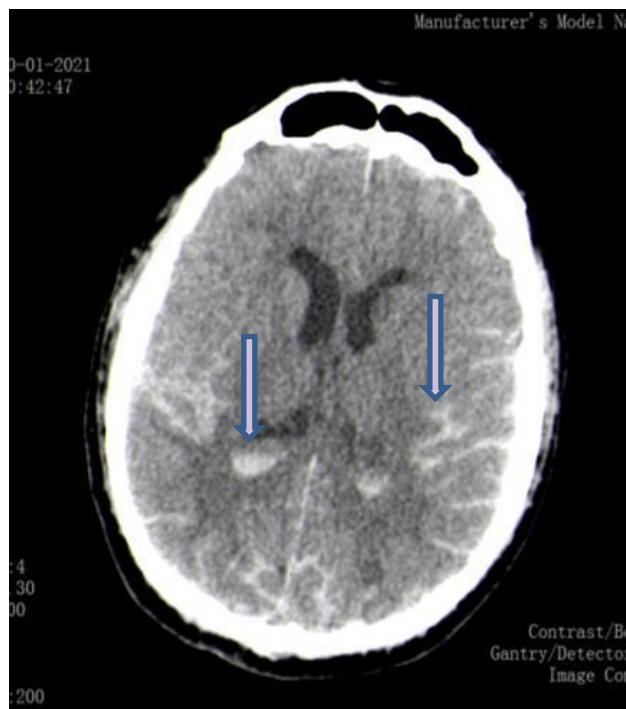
Non-contrast CT scan of the brain showing extensive SAH and IVH (arrows).
